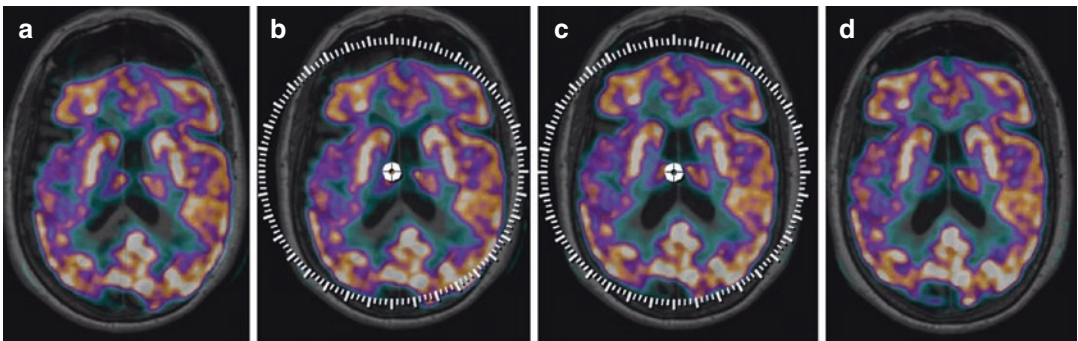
Brain ^{18}F -FDG PET/MRI with motion artifacts. During the post-processing is possible to correctly fuse PET and MRI data in few steps (a, b, c) in order to obtain an optimal realignment of both scans (d)
